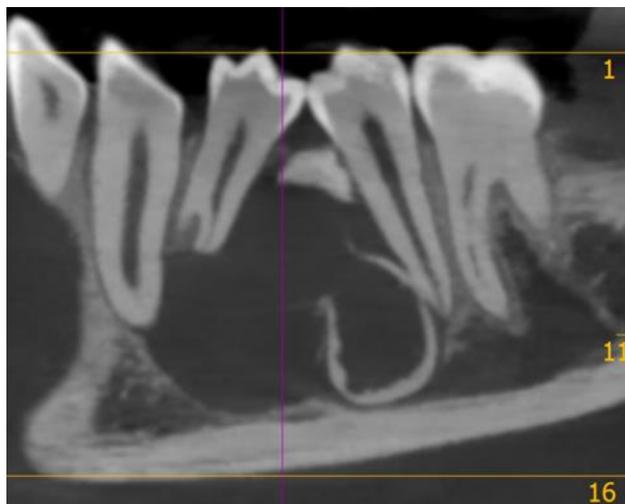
CBCT showing well-defined ovoid hypodense lesion with 2 focal hyperdense areas between the left mandibular premolar. Roots of premolar appeared to be diverged with resorption of root of I premolar, cortical outline of inferior alveolar nerve canal.
